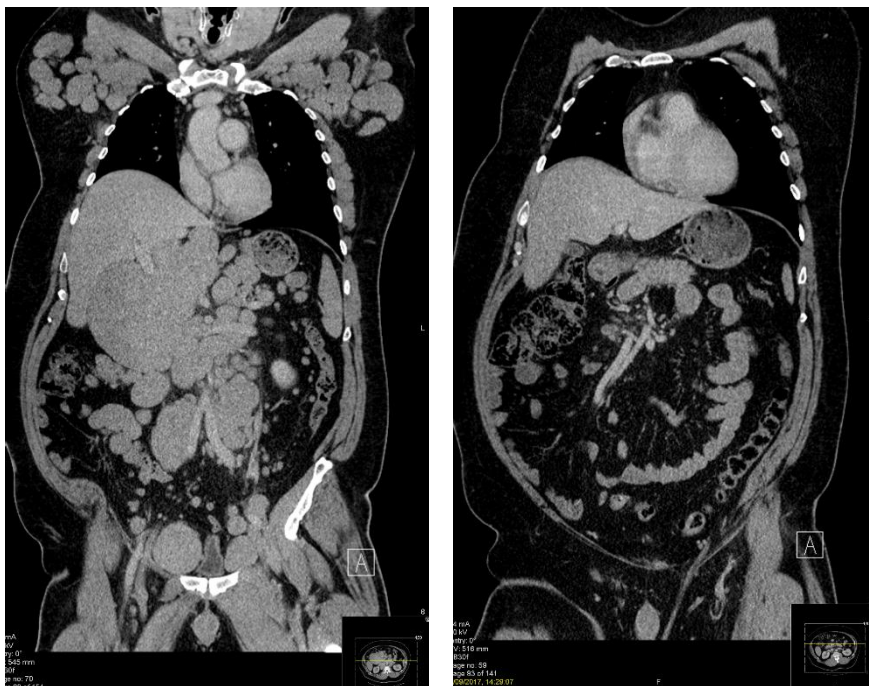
Figure Left: Swollen lymph glands (enlarged lymph nodes) in armpits and tummy (abdomen) on a CT scan at diagnosis. Figure Right: Good quality response to treatment. © The Royal Marsden NHS Foundation Trust
